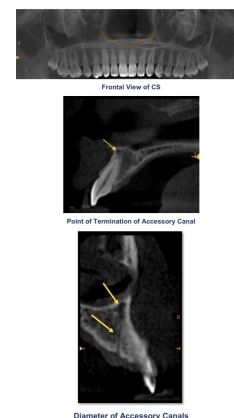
CBCT sections demonstrating the course of the canalis sinuosus. (A–L)
